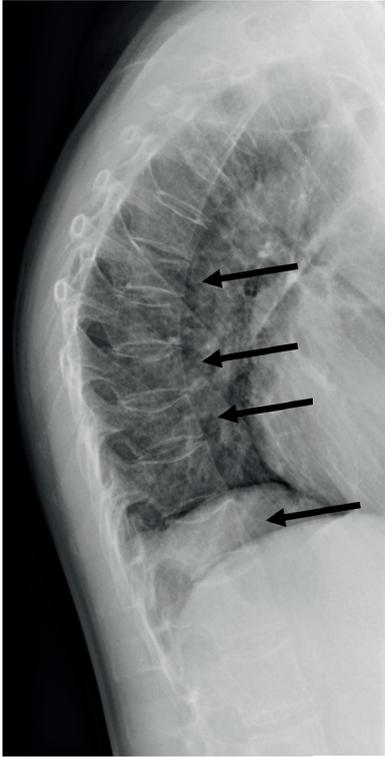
Lateral spinal X-ray image of the index patient. The black arrows show endplate compressions of thoracic vertebrae at T7, T9, T10, and T12.
